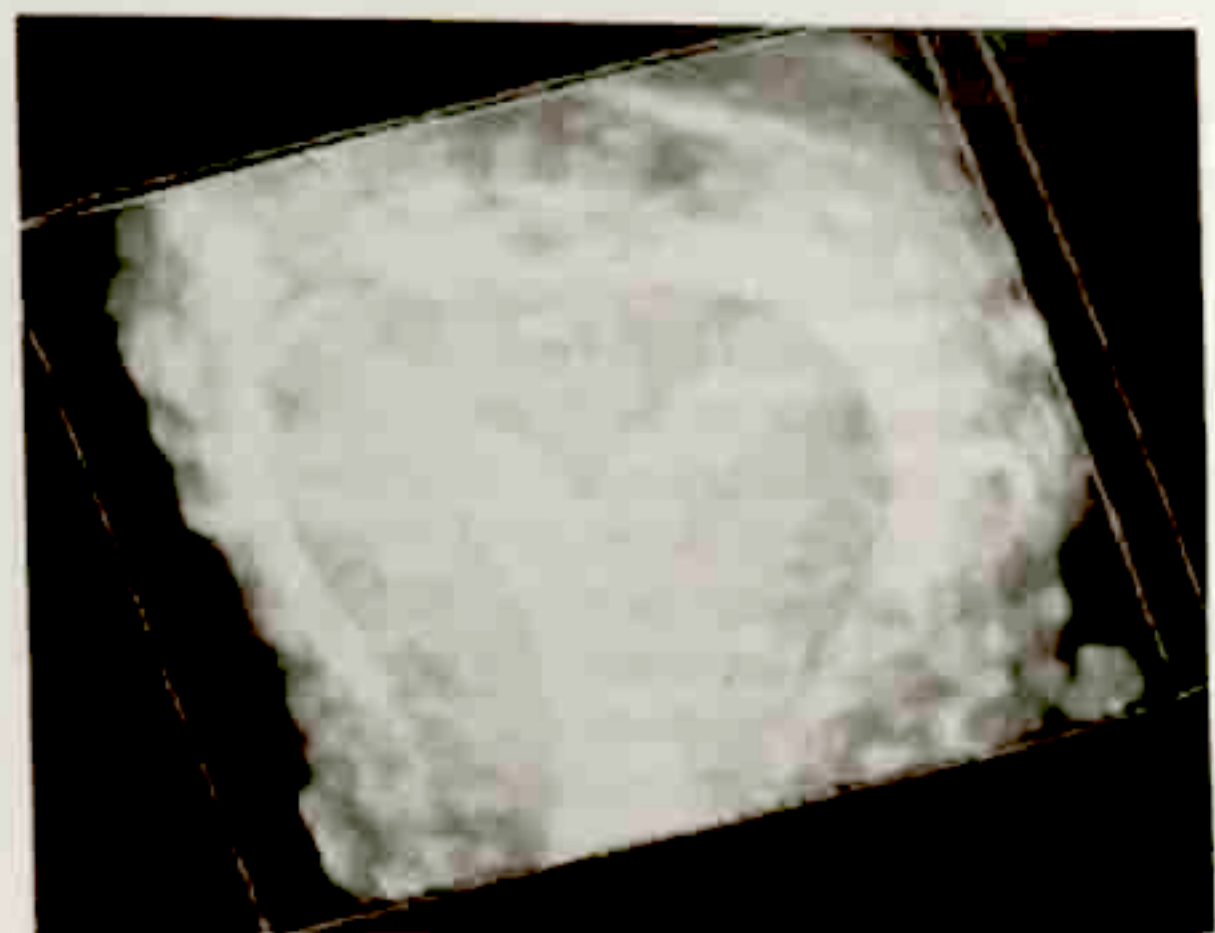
Three-dimensional ultrasound showing the uterine septum from the mid segment towards the fundus, with a flat outer fundal contour.
